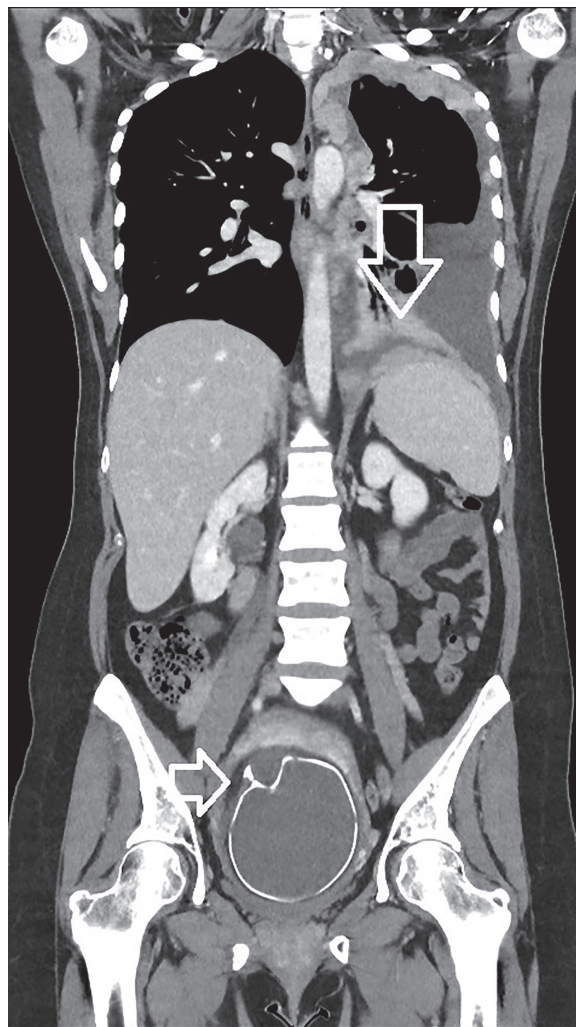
“The Two Growths” - Winning case of the first “Images in Pulmonology” contest. Coronal contrast-enhanced chest-abdomen CT scan demonstrating ALK-positive lung adenocarcinoma with pleural metastases in the left hemithorax (upper arrow) and a healthy fetus at 32 weeks’ gestation in utero (lower arrow). This remarkable image simultaneously captures two contrasting forms of cellular growth: malignant proliferation and new life. The patient successfully delivered a healthy baby and remains on targeted therapy with excellent disease control three years later, exemplifying the transformative potential of precision oncology in complex clinical scenarios.
